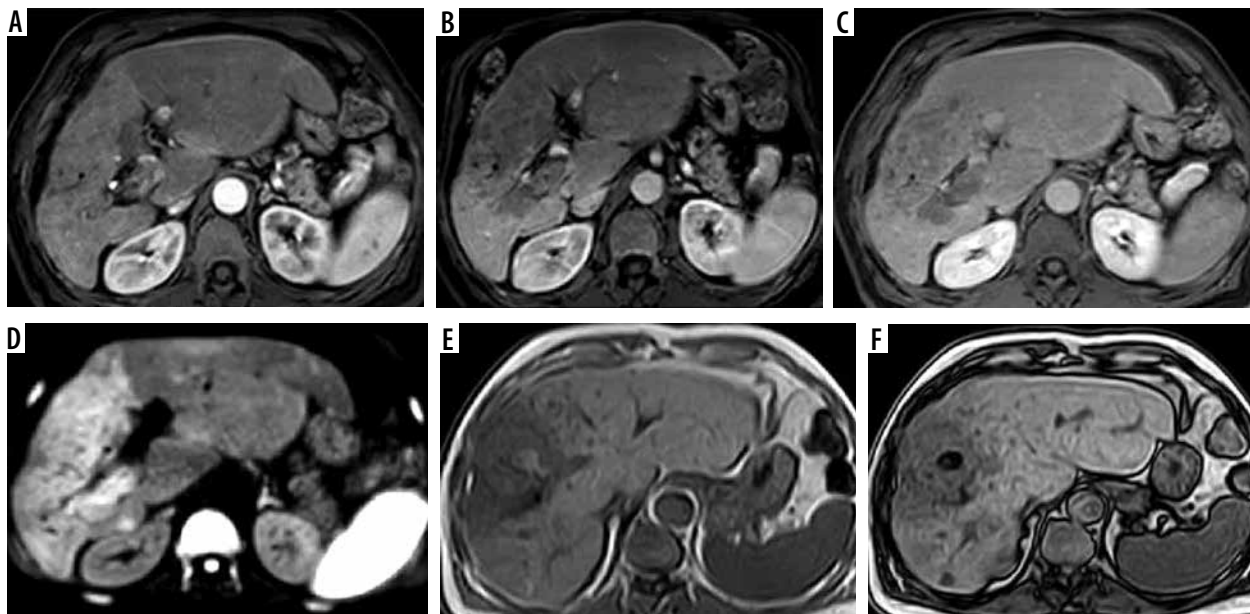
LR-TIV. A) Arterial phase image shows an infiltrative lesion with tumoral vein thrombosis in the right portal vein with arterial hyperenhancement. B, C) Portal venous (B) and delayed (C) phases show washout. D) Diffusion-weighted imaging shows diffusion restriction. E, F) Foci of bright signal are seen in axial T1-weighted image (E) showing loss of signal in out-of-phase images (F) denoting fat content
